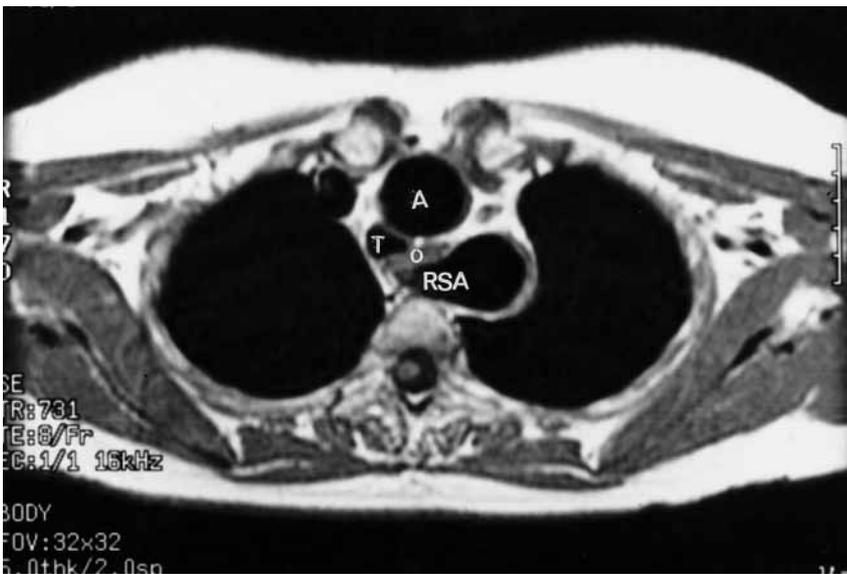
MRI scan cross-sectional slice showing an aberrant right subclavian artery (RSA) as it arises from the aorta, before passing superiorly and to the right to lie behind the trachea. O – oesophagus. A – ascending aorta. T – trachea.
